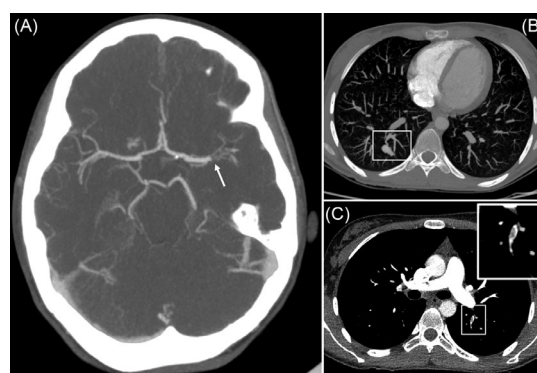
Panel A. Brain computed tomography angiography (CTA). Complete occlusion of left medium cerebral artery. Panel B. LungCTA. Typical arteriovenous malformations. Panel C. Lung CTA. Repletion defects in subsegmental pulmonary arteries (*amplified in the inset*).
